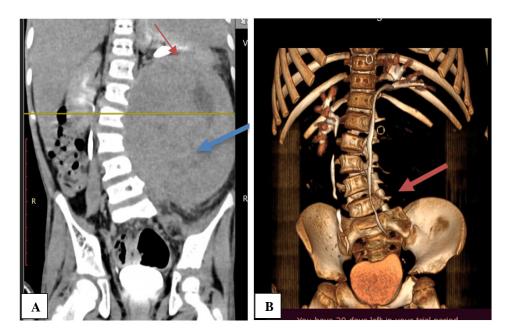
(A) In this case of retroperitoneal mass, on coronal reformatted MIP images of delayed phase of CT urography, the mass (blue arrow) is seen displacing left ureter (red arrow) and left kidney; B) In this case of retroperitoneal mass, on coronal reformatted MIP images of delayed phase of CT urography, the mass (blue arrow) is seen displacing left ureter (red arrow) and left kidney.
